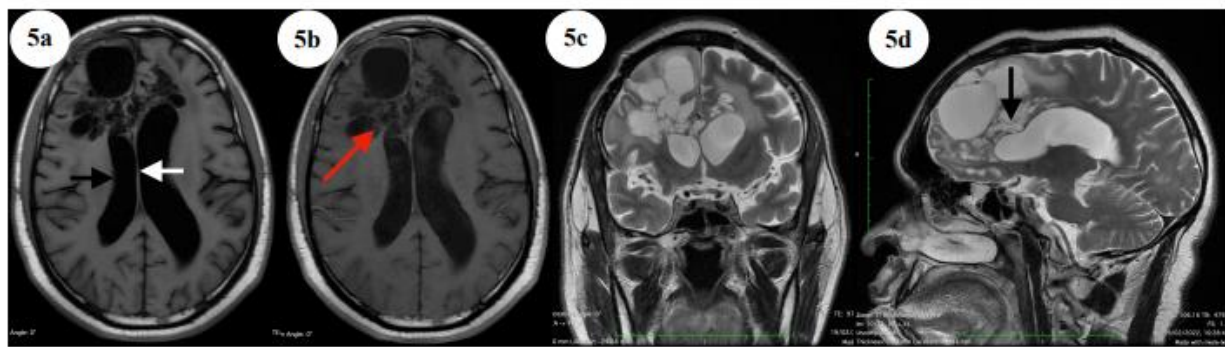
(a-d): Brain Magnetic Resonance Imaging (18 months post-initial operation; 6 months post re-operation; 3 months post-chemoradiotherapy).
